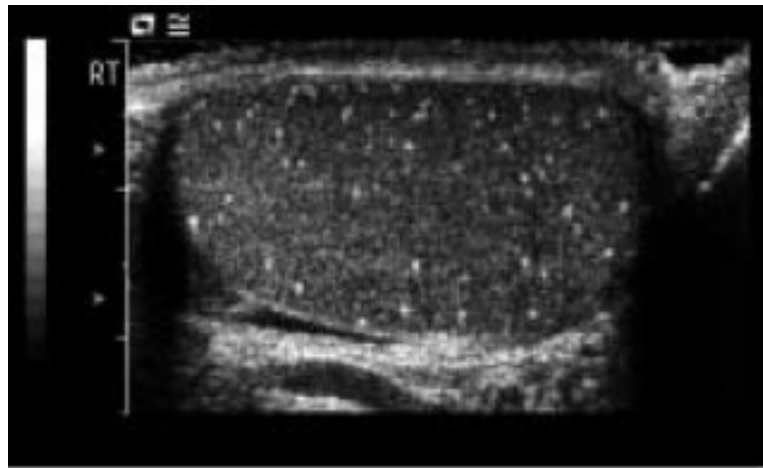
Typical ultrasound appearance of testicular microlithiasis with high reflective areas of microlithiasis on the background of a low reflective testis. (Taken from Doherty et al., 1987).
